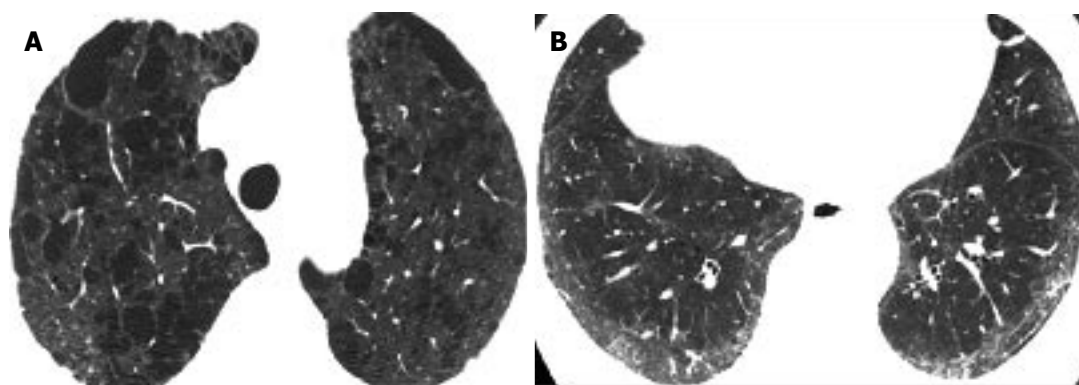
Centrilobular emphysema and nonspecific interstitial pneumonia-pattern of pulmonary fibrosis. A: High resolution computed tomography (HRCT) at the level of the upper lobes shows extensive predominantly centrilobular emphysema; B: HRCT of the same patient as in A, at the level of the lower lobes shows subpleural fine fibrosis characterized mainly by ground glass opacity, reticular pattern non-otherwise specified and absence of honeycombing. The HRCT pattern is consistent more with nonspecific interstitial pneumonia.
